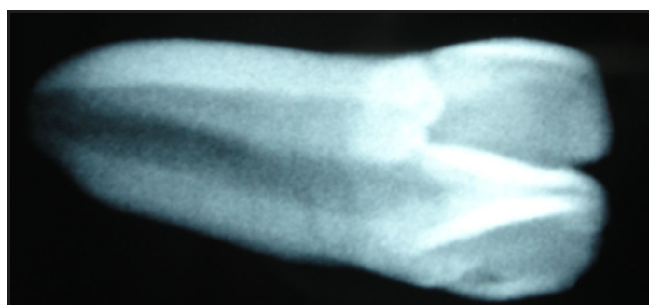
Digital radiograph of extracted tooth
